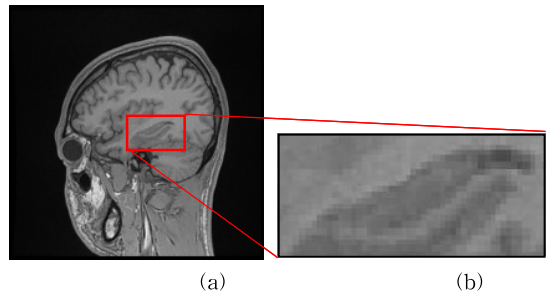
(a) Original MR image and (b)Cropped region of interest.
